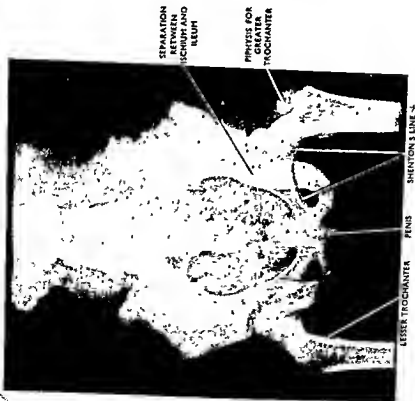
The antero-posterior radiograph of the pelvis and lower abdomen. Explanatory notes. Note the Shenton's line which forms an uniform curved line between the upper margin of the obturator foramen and the lower margin of the neck of the femur. Note also the lesser trochanter which ossifies between twelfth and fourteenth years. The head of the femur, which completely unites with the shaft between eighteenth and nineteenth years, is seen partially united. Thus the age of the subject would be about eighteenth year.
